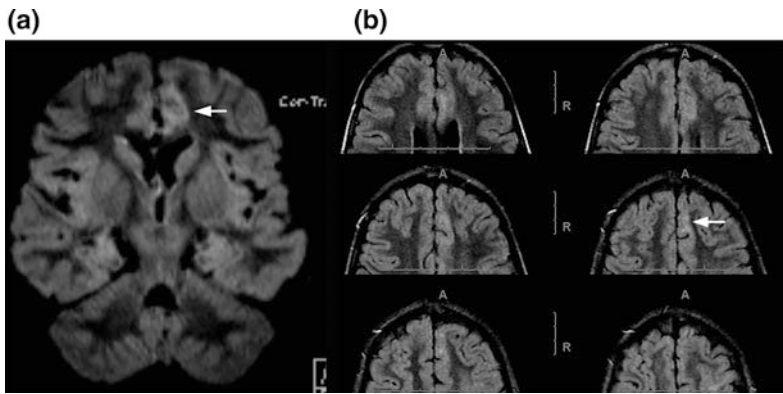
Coronal FLAIR MRI (a) and serial axial FLAIR MRI of the frontal lobes (b) demonstrating subtle gray-white blurring and FLAIR hyperintensity in the left
